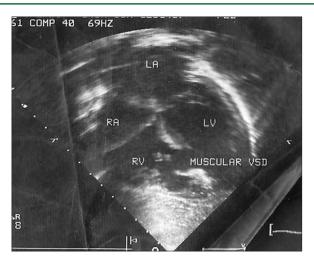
Two-dimensional echocardiography picture of the ventricular septal defect also showing the flap
